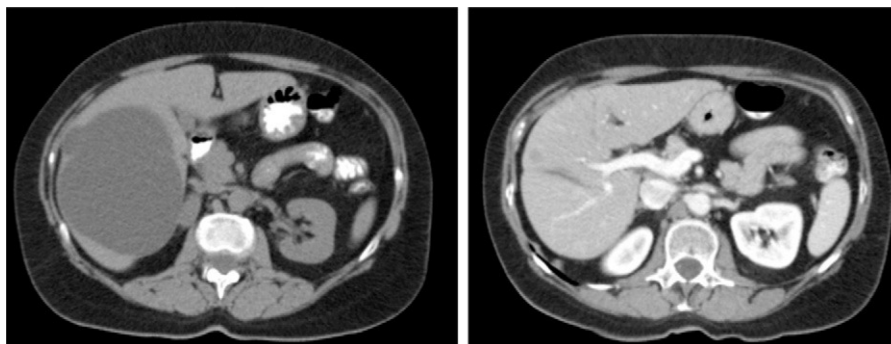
Abdominal CT: laparoscopic pre-fenestration and post-fenestration simple cyst.
